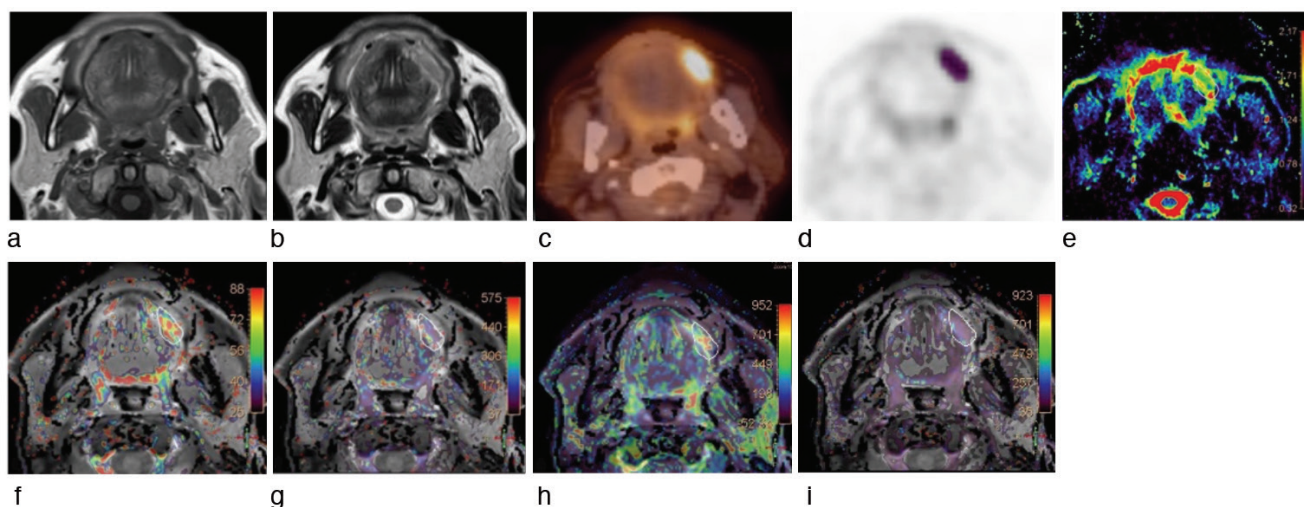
Imaging findings in a 61-year-old man with squamous cell carcinoma of the tongue ($T_2N_1M_0$). (a, b, c) T1- and T2-weighted images and ^{18}F fluorine-fluorodeoxyglucose imaging (fused image) show left-sided tongue lesion [maximum standard uptake value (SUV_{max}): 10.2; SUV_{mean} : 5.3]. (d) Showing attenuation-corrected positron emission tomography image in LIFx. (e) ADC map. The ADC values ($\times 10^{-3} \text{ mm}^2\text{s}^{-1}$) of the lesion are as follows: ADC_{min} : 0.2, ADC_{mean} : 1.07, and ADC_{max} : 1.9. (f, g, h, i) Dynamic contrast-enhanced (DCE) imaging findings. Estimated DCE parameters are as follows: (f) K_{trans} : $58.7 (\times 10^{-3} \text{ min}^{-1})$, (g) Ke_p : $303.1 (\times 10^{-3} \text{ min}^{-1})$, (h) Ve : $193.7 (\times 10^3)$, (i) $iAUC$: 159.1
